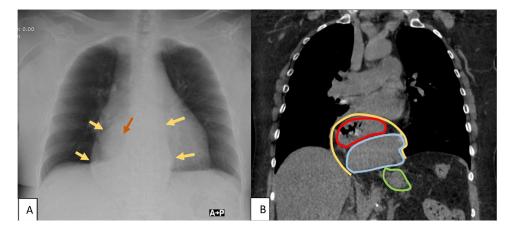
Posterior mediastinal mass associated with hydroair level, suggestive of gastrointestinal origin. (A) X-ray of anteroposterior thorax (AP) with evidence of radio-opaque image projected at the posterior mediastinal level (yellow arrows) with hydroair level (red arrow). (B) Thorax tomography in window of mediastinum in coronal reconstruction that shows hernial sac (yellow line), within the intrathoracic hernial sac the presence of gastric floor with alteration in its axis (red line), spleen (blue line), and with centralized pancreatic tail and cephalization (green line).
